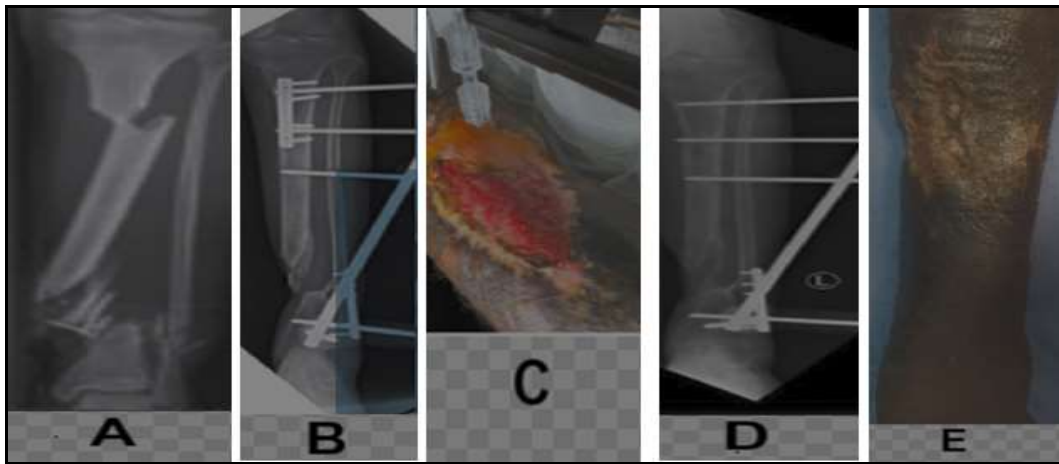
a 41-year-old man with septic pseudarthrosis of the right leg. A: initial x-ray of the tibia, frontal view. B: leg x-ray at the time of diagnosis of septic pseudarthrosis, frontal view. C: fleshy bud stage after a long period of irrigation. D: bone consolidation. F: Healing of the wound.
